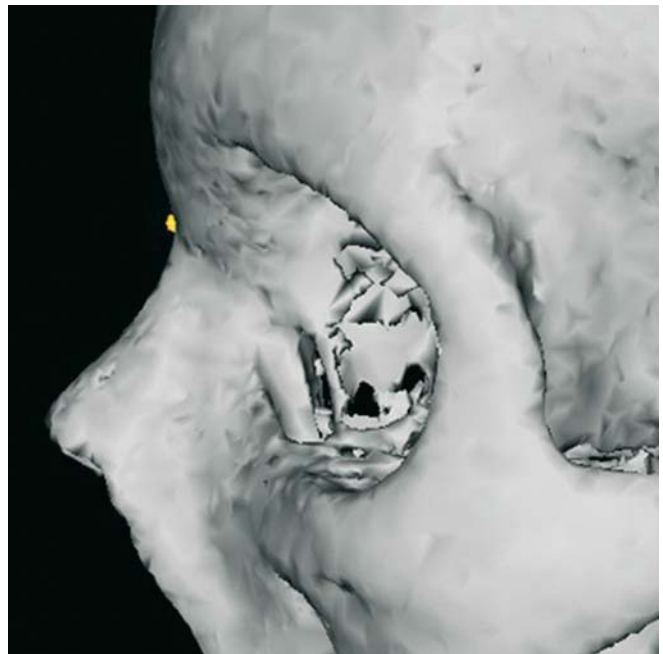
Nasion. Profile view left (3-D CT, patient K.C.)
